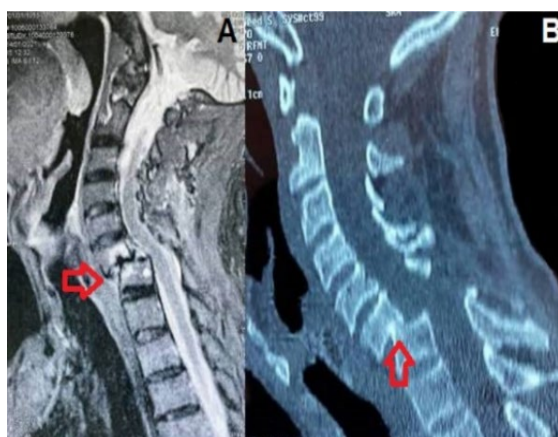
MRI: Sagittal view of T2 weight image of the cervical spine showing dislocation at C6-C7 without spinal cord compression (A). CT scan: Sagittal view of a CT scan of the cervical spine in the bone window showing a dislocation at C6-C7 (B).
